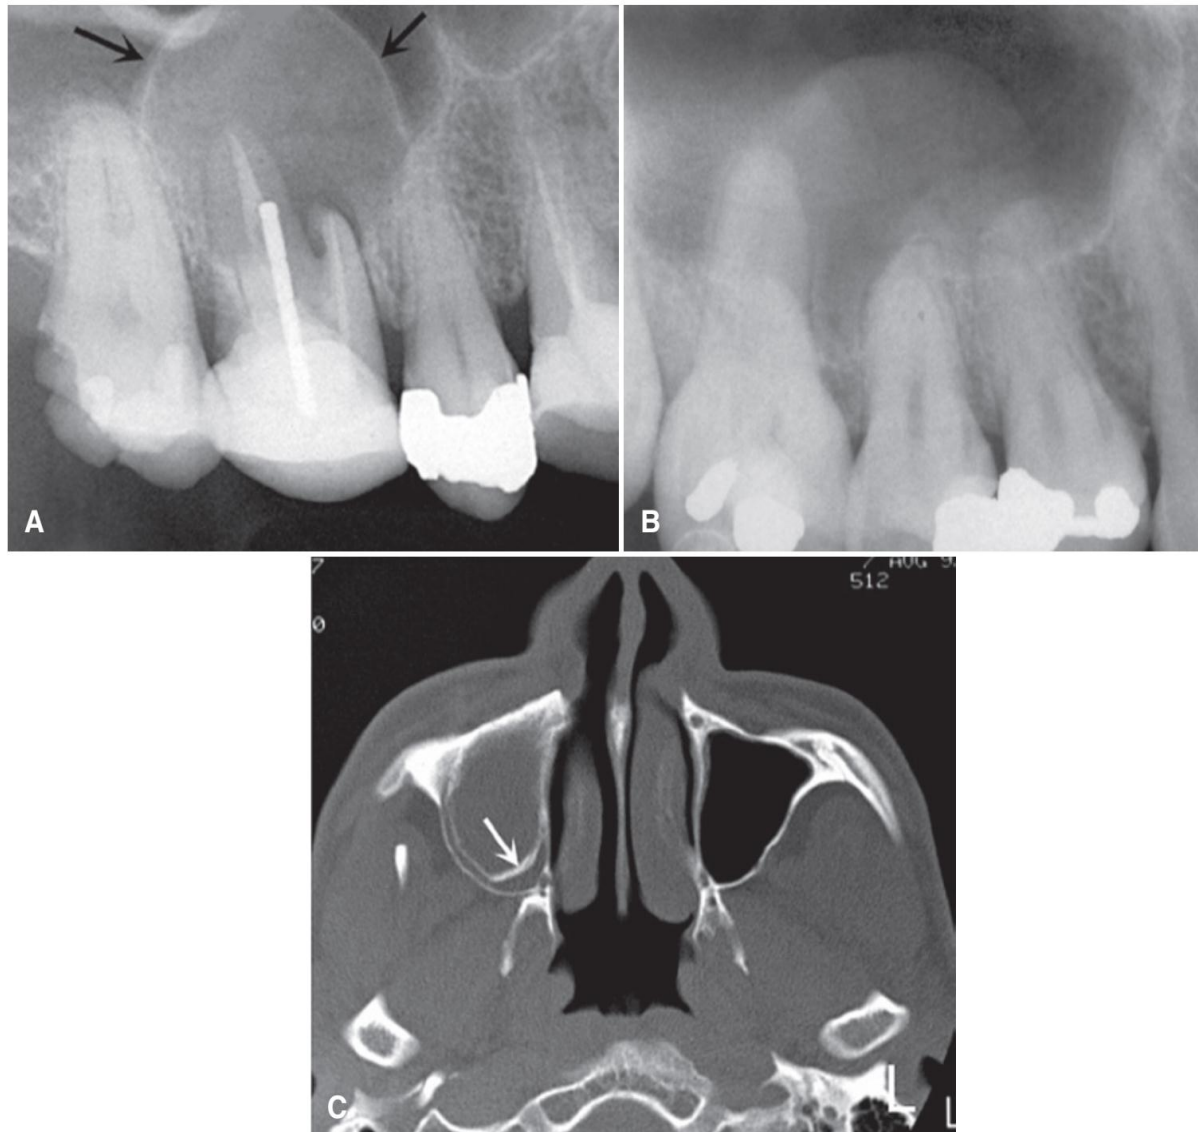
(A) Periapical image of rarefying osteitis (in this case, a small radicular cyst) associated with a maxillary molar tooth. Note the peripheral cortex (*arrows*). (B) Periapical image of a pseudocyst; note the lack of a peripheral cortex. (C) Axial computed tomography image of a large radicular cyst; note the peripheral cortex (*arrow*) inside the outer cortex of the sinus.
